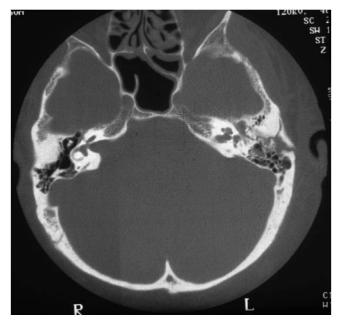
Temporal bone CT scan showing a longitudinal left temporal bone fracture in a 60-year-old man with facial and vestibulocochlear nerve palsy. Otorrhagia and impairment of audition were associated with the facial palsy, which had not improved by the end of the follow-up period.
